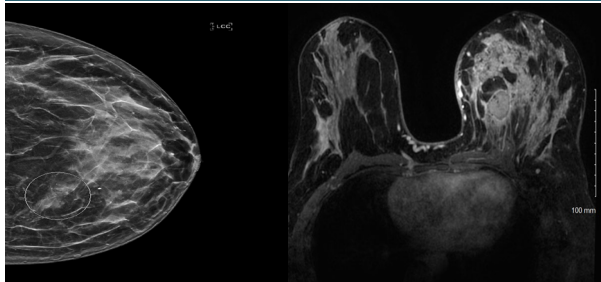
Breast MRI image showing 3 cm mass
